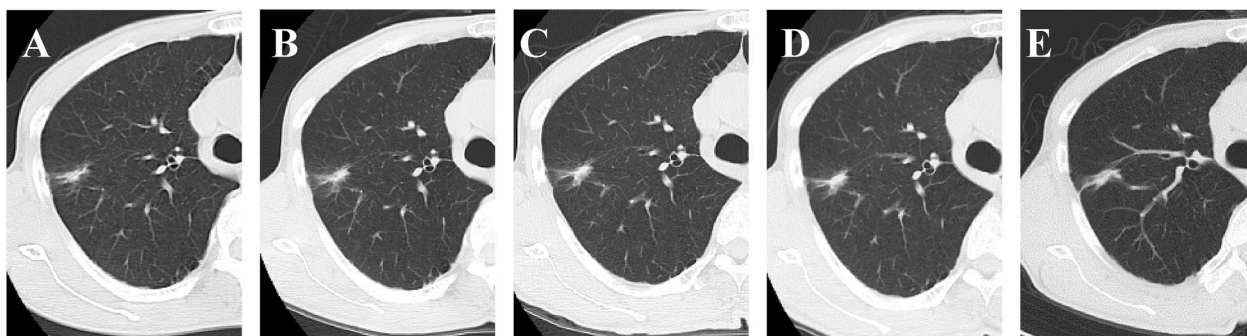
Chest computed tomography of the nodule in the upper lobe of the right lung. No change was observed during the course of observation. A. The nodule when it was first detected. B. Ten months after the time from 1A. C. Eighteen months after the time from 1B (the same period represented in Fig. 4A). D. Twelve months after the time represented in Fig. 1C (the same period represented in Fig. 4B). E. Eighteen months after the time from Fig. 1C (the same period represented in Fig. 4C).
